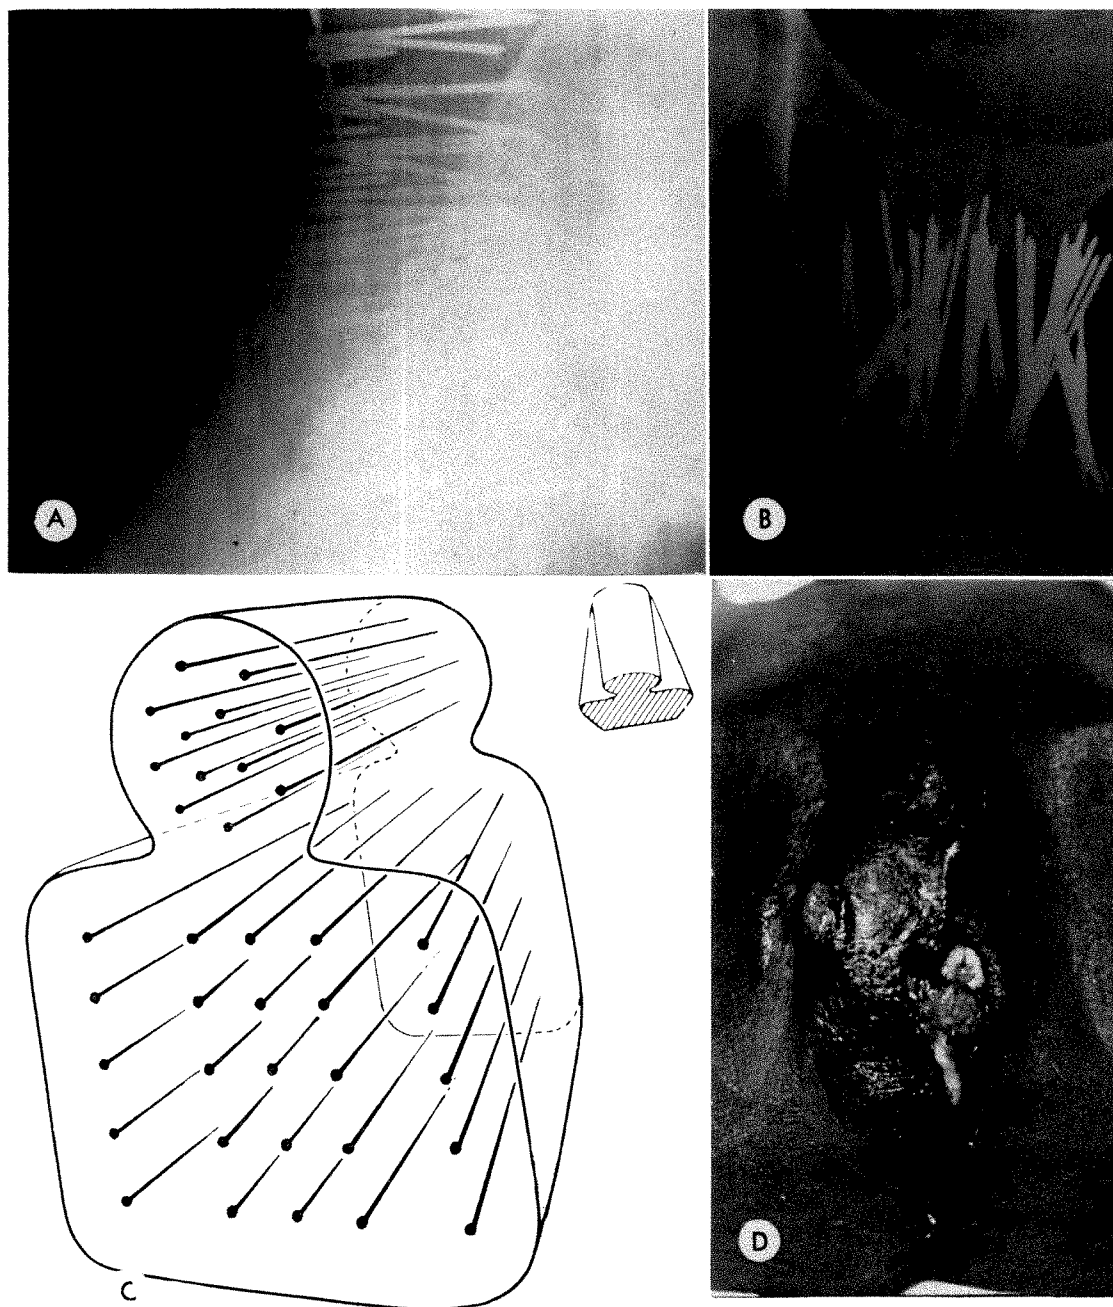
M.C. 48 N.M. *Recurrent squamous cell carcinoma after radical amputation for carcinoma of the penis.* It was decided to use combined 220 kv. roentgen therapy and radium implantation.
